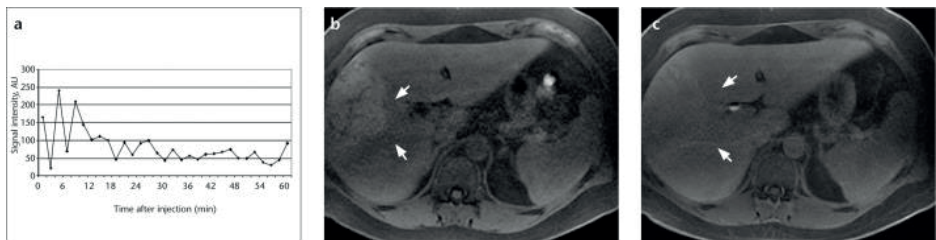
/b/c. Enhancement curve (a) of a known inflammatory HCA that was scanned every 2.5 min over a period of one hour following the injection of gadobenate dimeglumine. This approach allows an enhancement curve that shows no late enhancement to be reproduced. Comparison of axial fat-saturated T1-weighted sequences prior to contrast injection (b) and one hour after contrast injection (c) reveals that the lesion remains isointense (arrows) due to intrinsic hyperintensity
